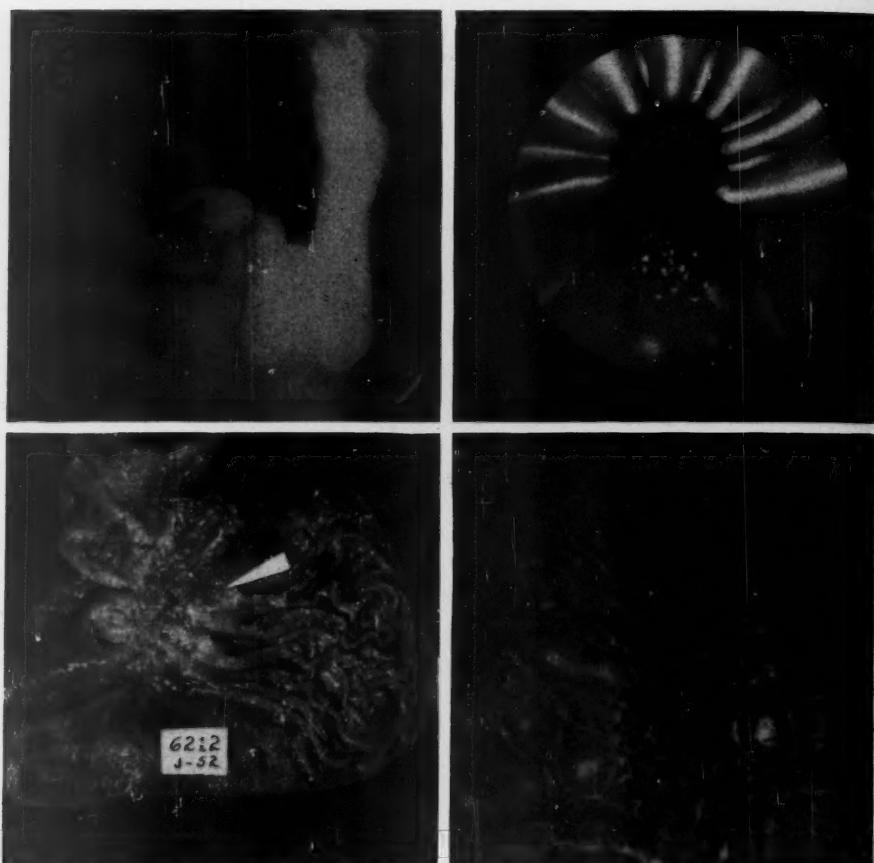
(Top left). X-ray revealed a small shallow crater midway of the lesser curvature with nothing to suggest malignancy.
